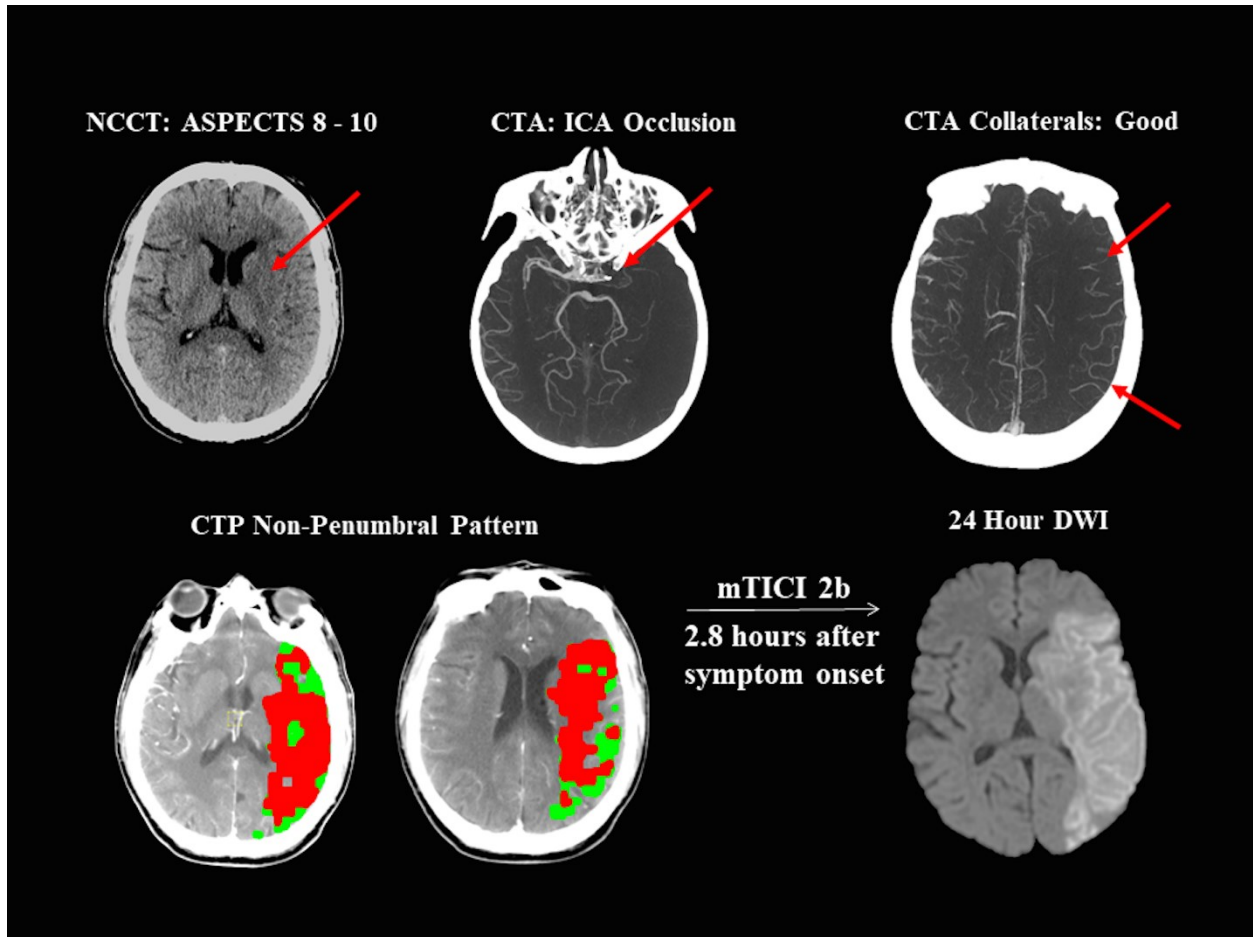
Non-Target Mismatch Patient. Acute CT and 24 hour follow-up diffusion-weighted magnetic resonance imaging (DWI) in a 59 year old man treated with tPA, followed by endovascular clot retrieval. Baseline non-contrast CT (NCCT) ASPECTS was between 8 (arrows) and 10 (core lab). Multiphase CT angiography (CTA) demonstrated good collaterals. CT perfusion (CTP) demonstrated a large core, non-penumbra pattern (core (red) =153.4 mL; penumbra (green) =59.9 mL, mismatch ratio=1.4). Despite successful endovascular therapy and recanalization with mTICI 2b flow 2.8 hours after onset, 24 hour DWI infarct volume was 278.0 ml, and the day 90 modified Rankin Scale score was 4.
